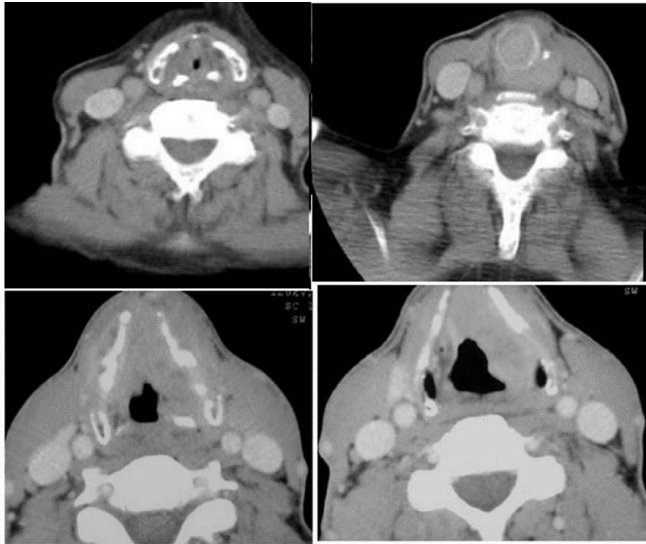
CT scan show a tumor process centered on the left vocal cord, extending to the anterior commissure, with lysis of the thyroid cartilage.
